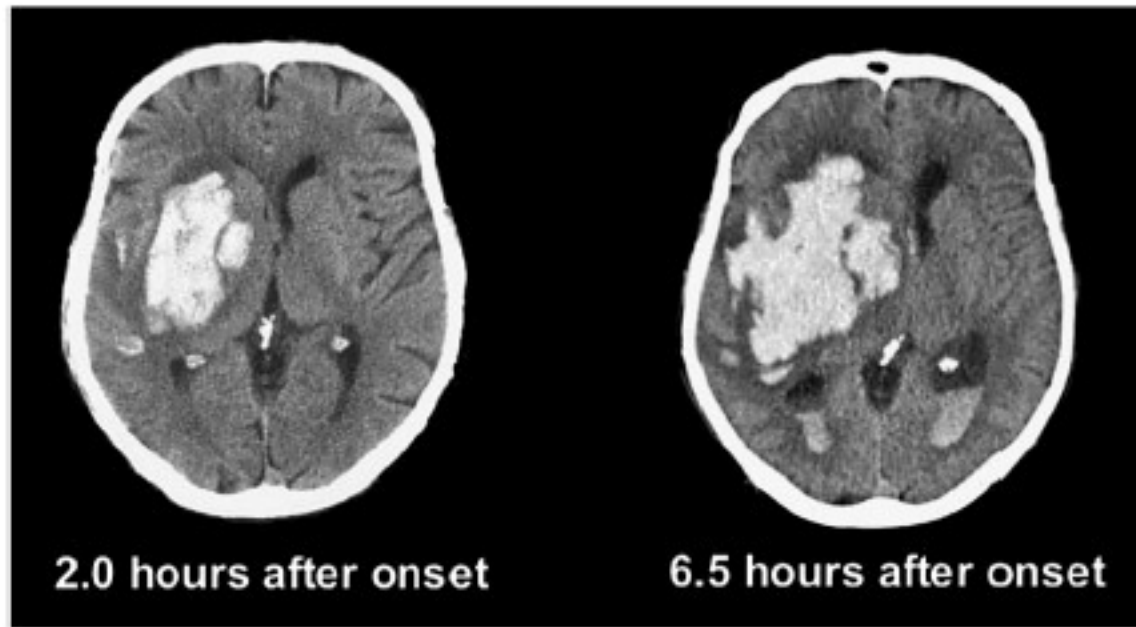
Early hematoma growth in a 48 year-old chronically hypertensive woman. Left: The baseline CT scan performed shows a moderate-sized right putamen ICH. At this point she is stuporous with a left hemiparesis. Right: A follow up CT performed after she deteriorated to coma with bilateral decerebrate posturing shows massive expansion of the hematoma, as well as new intraventricular hemorrhage and obstructive hydrocephalus. Within 24 h she was declared brain dead. From Mayer SA, Rincon F. Treatment of Intracerebral Hemorrhage. Lancet 2005, with permission.
